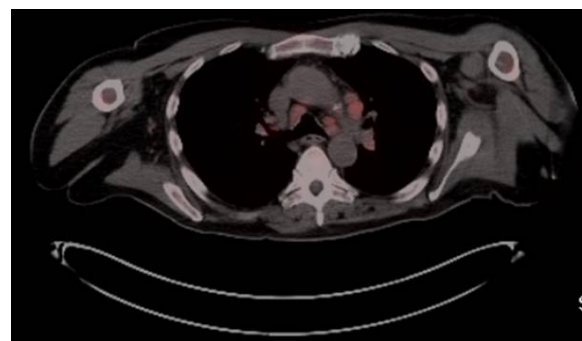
PET/CT transverse view showing multiple enlarged mediastinal and pulmonary hilar lymph nodes with intense FDG uptake.
